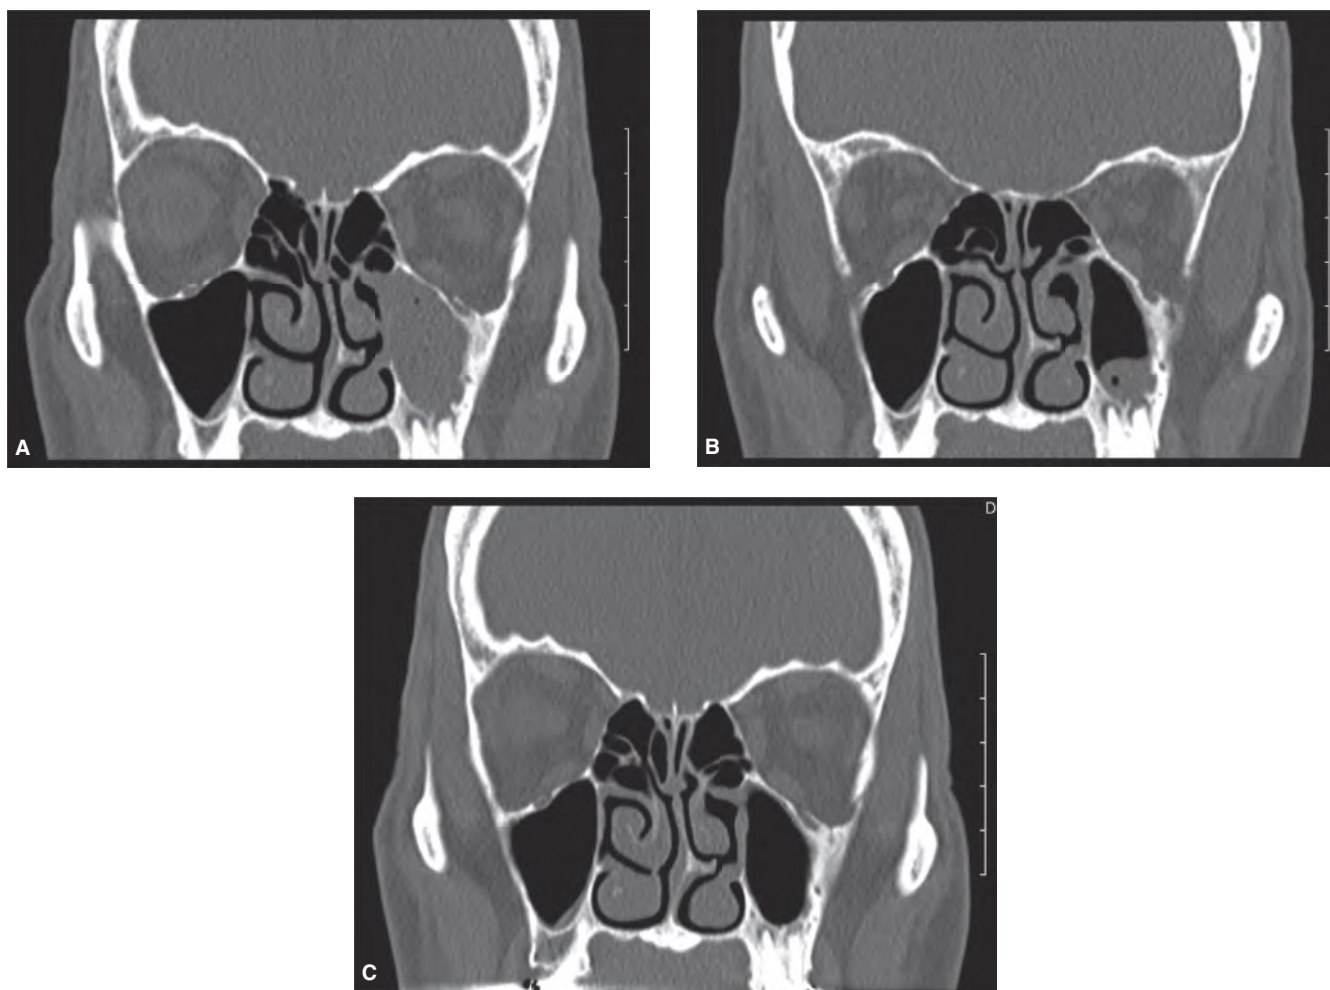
Odontogenic rhinosinusitis. A. Coronal CT image of a fully obstructed left maxillary sinus. The patient had experienced severe maxillary sinus infections for over 7 years with no resolution, despite multiple antibiotic regimens. He was scheduled for endoscopic sinus surgery when a periapical osteoperiostitis lesion was noted over the apices of the maxillary left second molar. Endodontic treatment was recommended prior to proceeding with surgery. B. 4-week postoperative coronal CT image showing significant improvement of the condition in the left maxillary sinus, with the air-fluid level less than 50%. C. 10-week postoperative coronal CT image showing full resolution of the sinusitis in the left maxillary sinus. No other sinus treatment was performed nor antibiotics administered. All symptoms had resolved and the patient's sinus surgery was cancelled.
